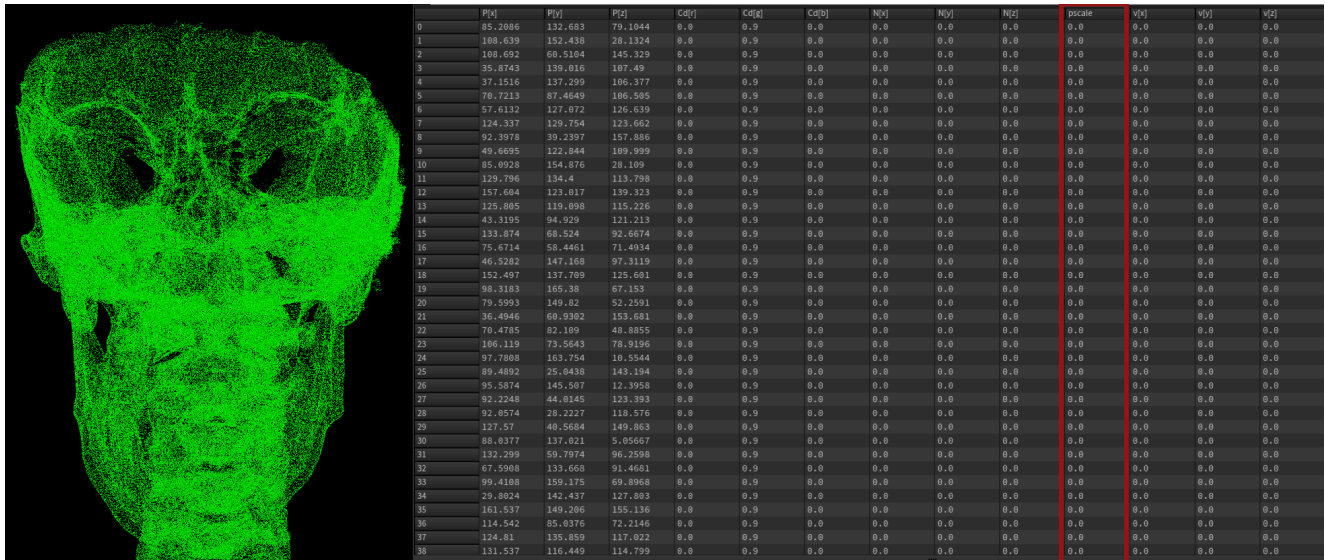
Analysis conducted on the same CBCT shows zero changes proving that, if we exclude the error from segmentation and registration, the program has a perfect sensitivity.
